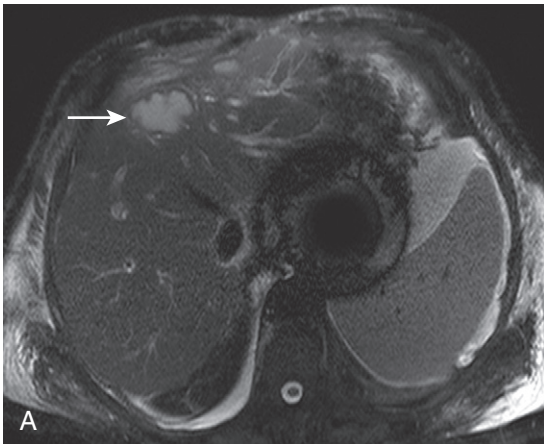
Hepatic infarct. The T2-weighted fat-saturated image (A) shows a round, subcapsular hyperintensity (*arrow*), which lacks enhancement on the postcontrast image (*arrow* in B), corresponding to an infarct in a transplanted liver. The susceptibility artifact arises from embolization coils in esophageal varices.
